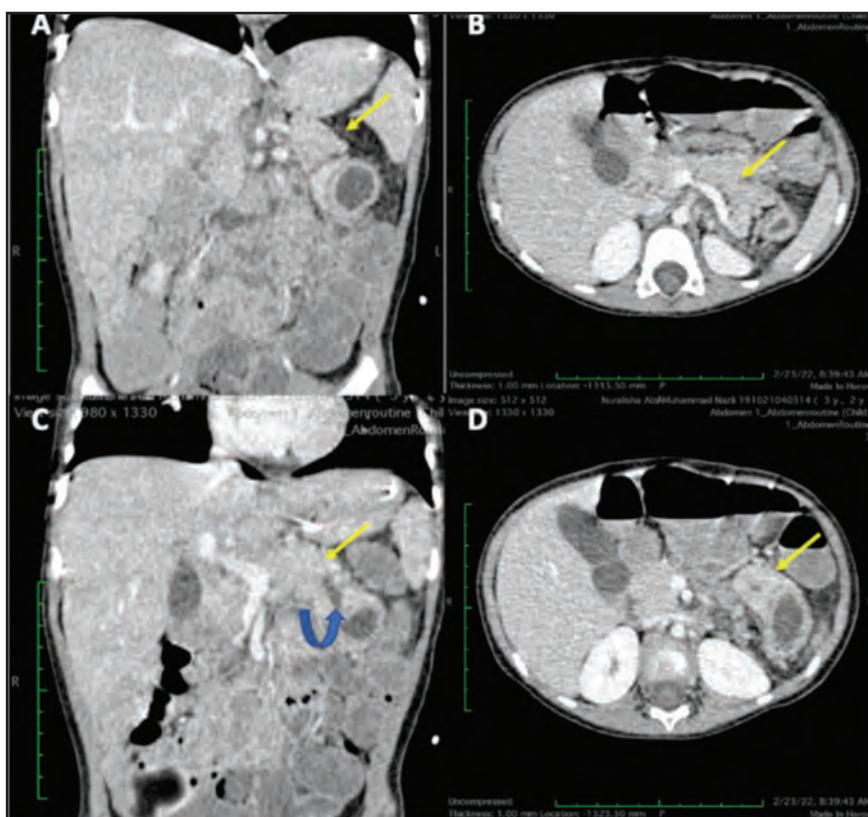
Contrast-enhanced CT abdomen on coronal reconstruction and axial view showing a bifid pancreatic tail with dorsal tail (A, B) and ventral tail (C, D). Note that the thick-walled cystic lesion is subjacent to the ventral tail of the pancreas, with a dilated distal pancreatic duct as denoted by curved arrow (C). Note that the thick wall cystic lesion has a claw sign with an adjacent ventral tail of the pancreas (D).
